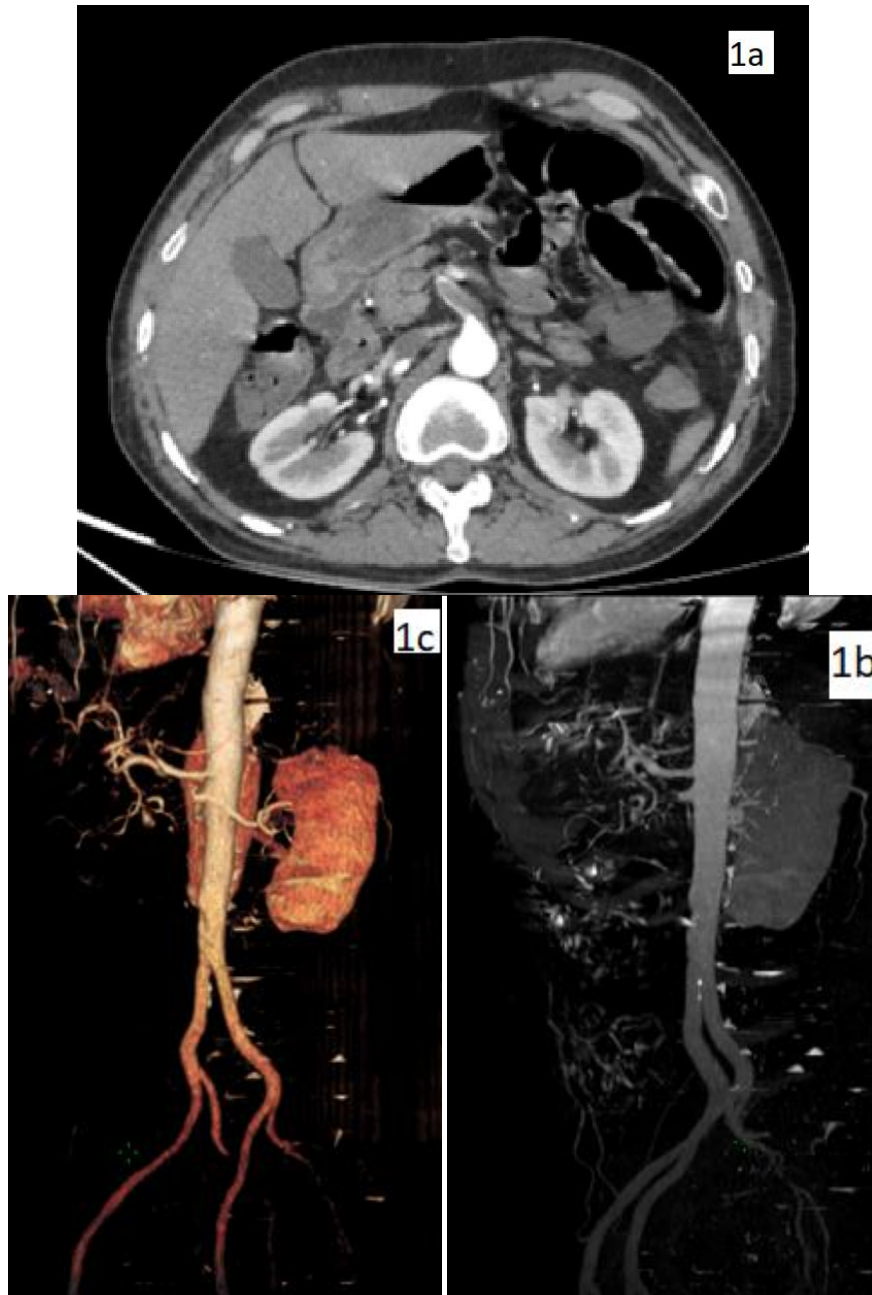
Axial CT angiography scan (1a) demonstrating an intraluminal filling defect in the superior mesenteric artery. Three-dimensional volume-rendered (VR) reconstructions (1b) et (1c) demonstrating occlusion of the superior mesenteric artery
